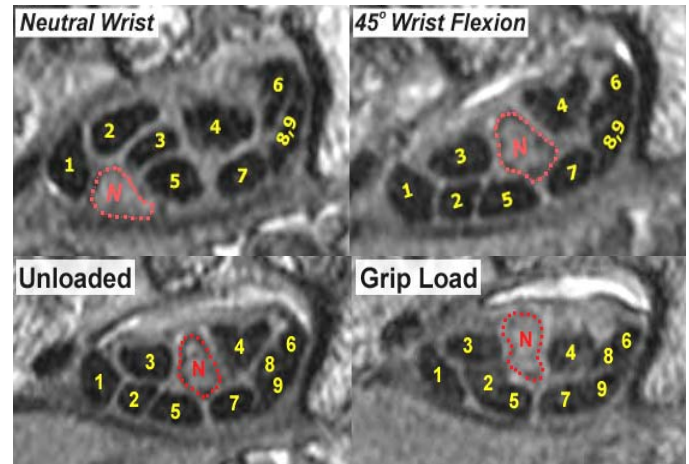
MR images of a single longitudinal section of the carpal tunnel during hand motion. Moving the unloaded wrist from straight to 45° of flexion caused the median nerve to extrude through the tendons (top). Movement from a relaxed to a squeeze grip loading caused changes in tendon and nerve shapes (bottom).
